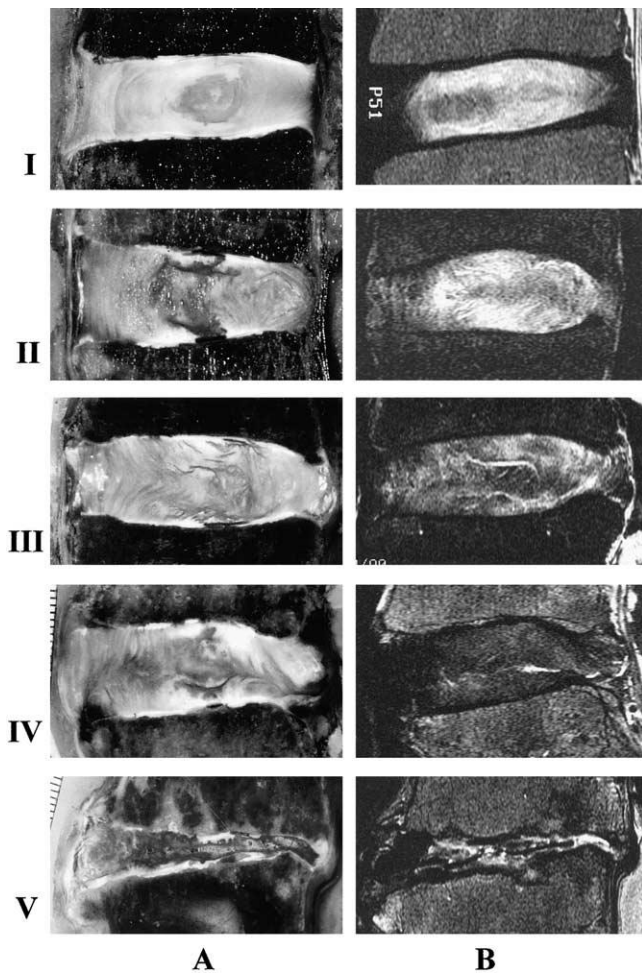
A) Photographs of the midsagittal cryomicrotome sections of the IVD with disc degeneration from grades I to V. B) T2-weighted midsagittal MR images of the IVD with disc degeneration from grades I to V (Tanaka et al., 2001).
